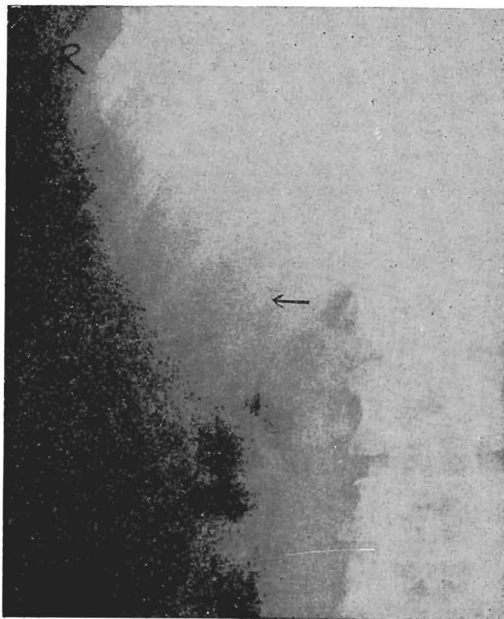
The plain film of the gallbladder region demonstrates radiopaque material in the gallbladder which is normal in size. Multiple minute lucent shadows are present in the fundus of the gallbladder.
